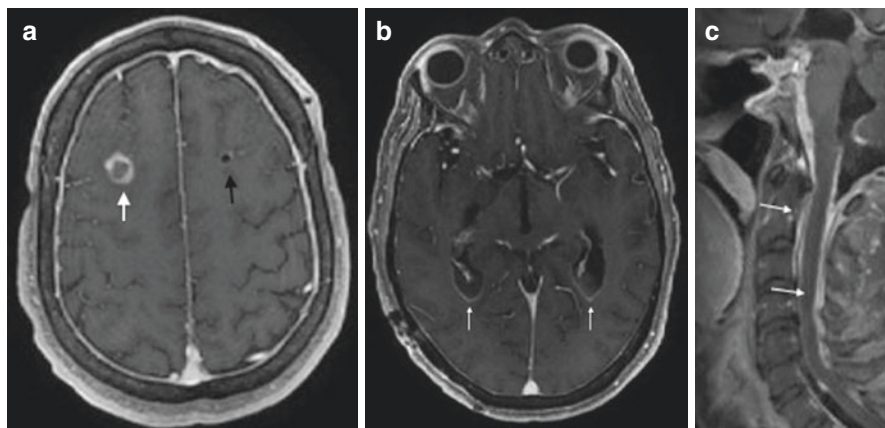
A patient with a history of type 2 diabetes mellitus and hydrocephalus, external ventriculostomy catheter placement presents, 10 days after ventriculostomy placement with fever, headache, and altered mental status, the catheter was removed and a new one in the other side was placed. Axial SPGR post-contrast MRI (a, b) shows (a) an exuberant enhancement on the path of the removed catheter (white arrow), (b) ependymal enhancement of the lateral ventricle (arrow). Sagittal T1 post-contrast (c) shows in the cervical spine enhancement on the surface of the subarachnoid space and nerve roots (arrow). These findings are consistent with ventriculitis with extension to the meninges and cervical nerves
